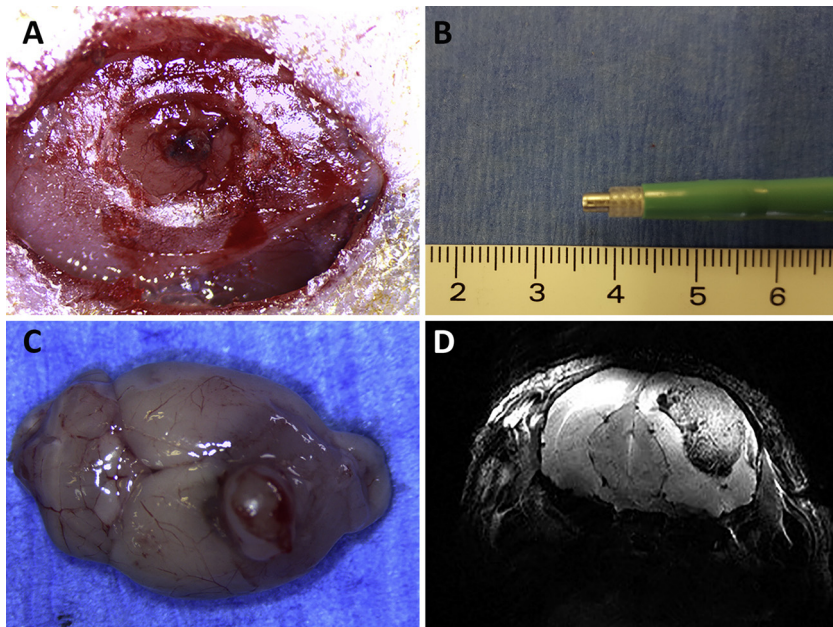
A: A cranial window at 13 days post inoculation. The dark, blood vessel rich central area corresponds to the tumour; B: A disposable 2 mm Ø biopsy punch limited to 3 mm in length used for tumour resection; C: Tumour recurrence at day 36; D: MRI scan showing the extent of recurrence at 31 days post resection.
